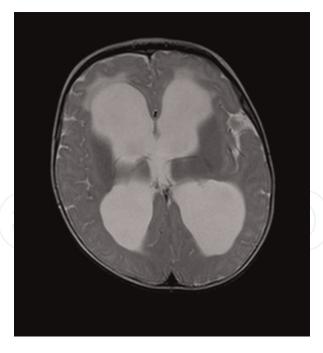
The MR image of the brain (axial section, T2-weighted image) of a child with active hydrocephalus. Significant dilatation of the cerebral ventricles is presented. The finding of periventricular edema and roundness of the horns of lateral cerebral ventricles indicates the activity of hydrocephalus.
